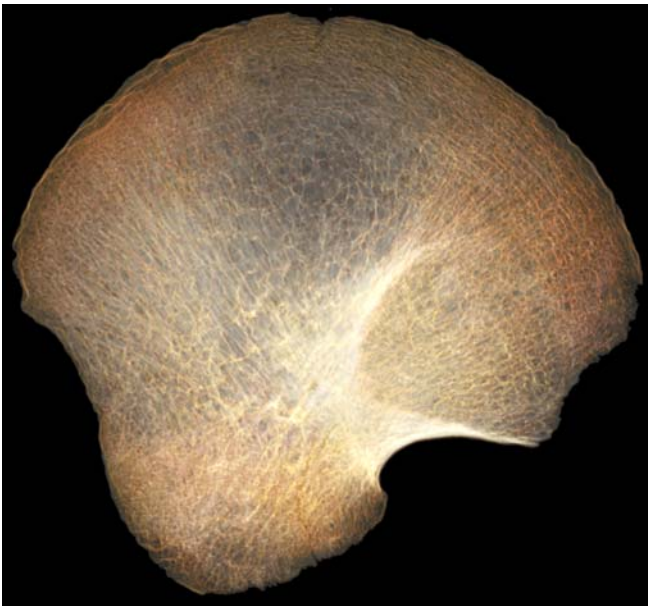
SR- μ CT-based 3D virtual reconstruction (45.5 μ m) of a modern juvenile (6–7 years old) human ilium (spec. SCR 749; Museum NPEP, Rome)
